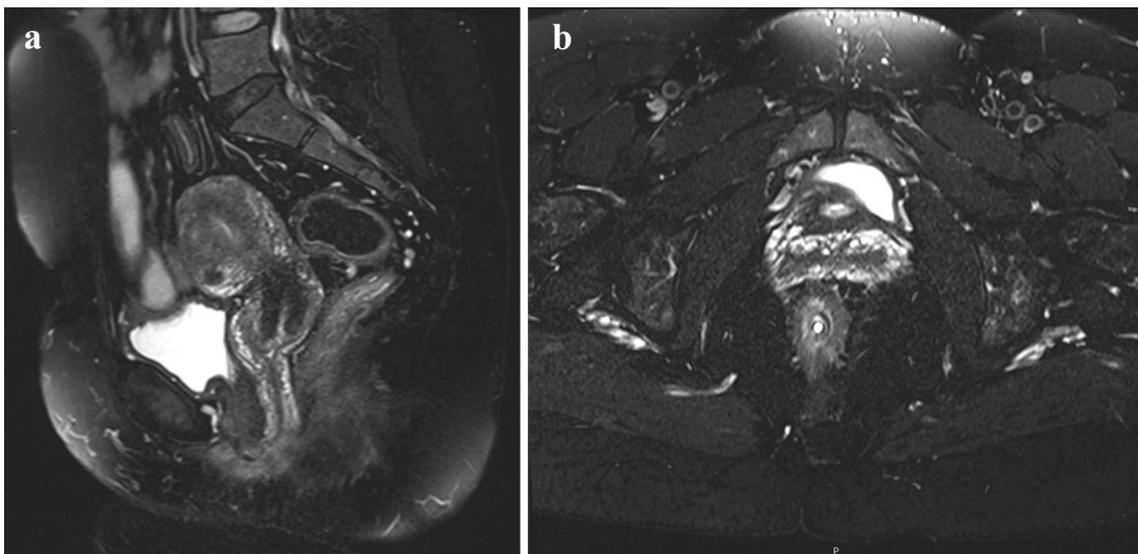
a Sagittal section from a pelvic MRI 1 year after starting IFX, revealing residual inflammatory signs, with no fistulous tracts. b Axial section from a pelvic MRI 1 year after starting IFX, revealing residual inflammatory signs, with no significant fistulous tracts
